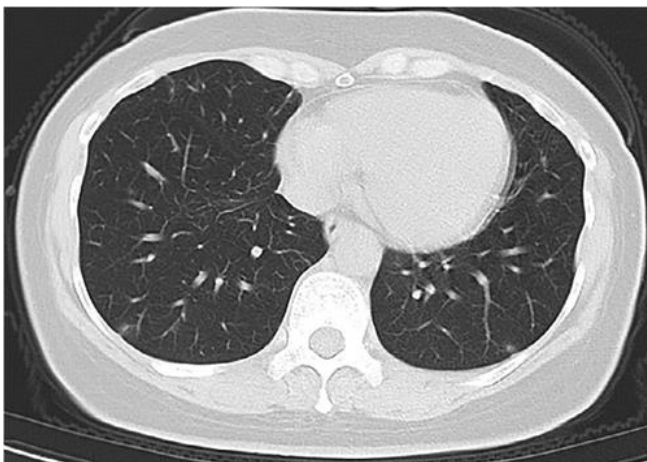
Atypical chest CT findings compatible with COVID-19 pneumonia showing bilateral subpleural ground glass opacities (GGO).
